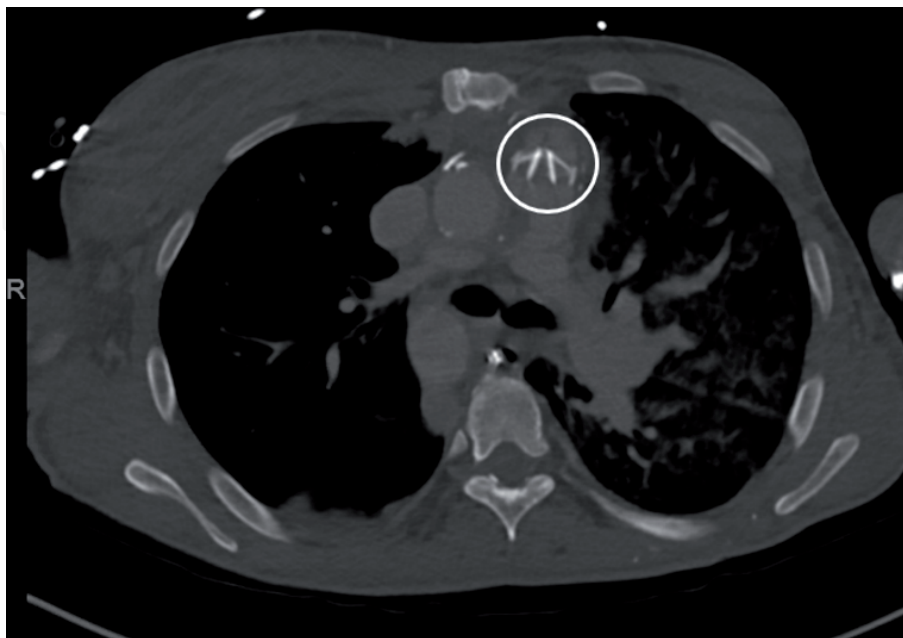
Computed tomography scan in a patient who underwent multiple previous sternotomies for an initial Rastelli procedure with subsequent multiple pulmonary conduits changes and has a bileaflet mechanical prosthesis in the pulmonary position (white circle).
